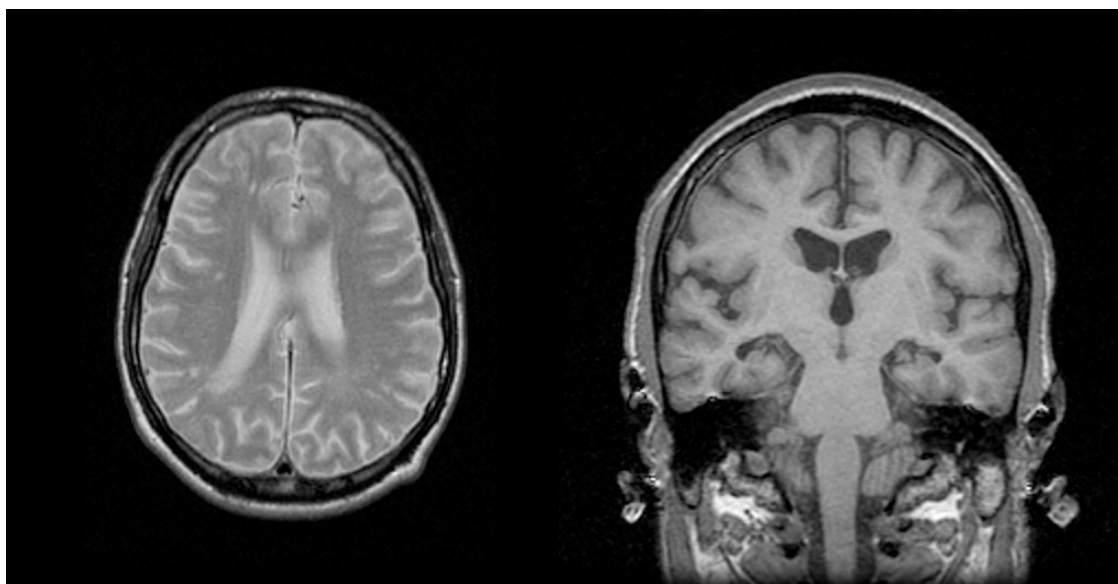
MRI scans from proband 1 showing extensive white matter abnormalities and an amygdala haemorrhage (arrow).
